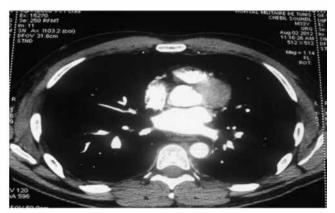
Chest CT scan: sub-segmental antero and postero basal pulmonary embolism at the right lower lobe
